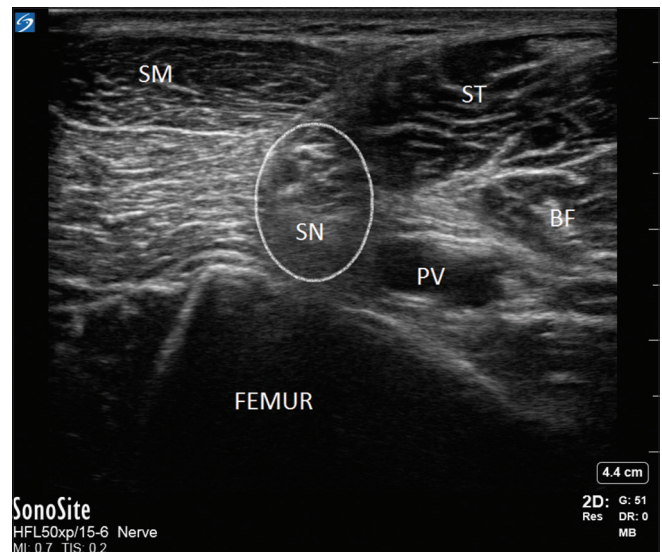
Ultrasonography image of the sciatic nerve. BF = biceps femoris, PV = popliteal vessels, SM = semimembranosus, SN = sciatic nerve, ST = semitendinosus
